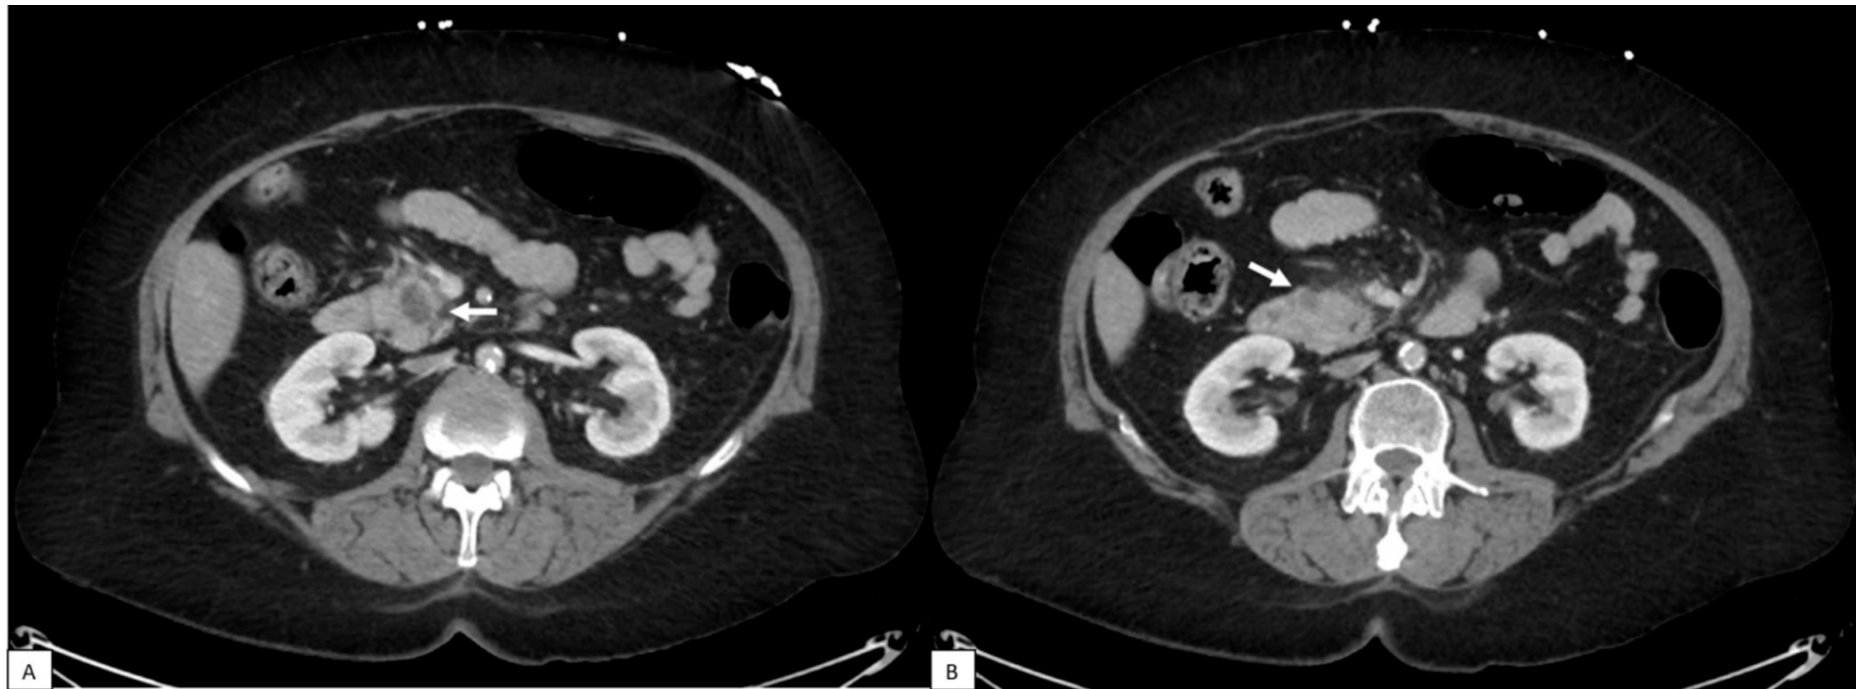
Abdominopelvic imaging demonstrating a new pancreatic mass. (A) CT scans of the abdomen and pelvis with contrast shows a new ellipsoid area of hypoenhancement within the pancreatic head near the region of the ampulla that measures 2.2 x 1.5 cm. (B) A separate area of hypo-enhancement seen more laterally and inferiorly measures 1 cm. The pancreatic duct is not distended.
